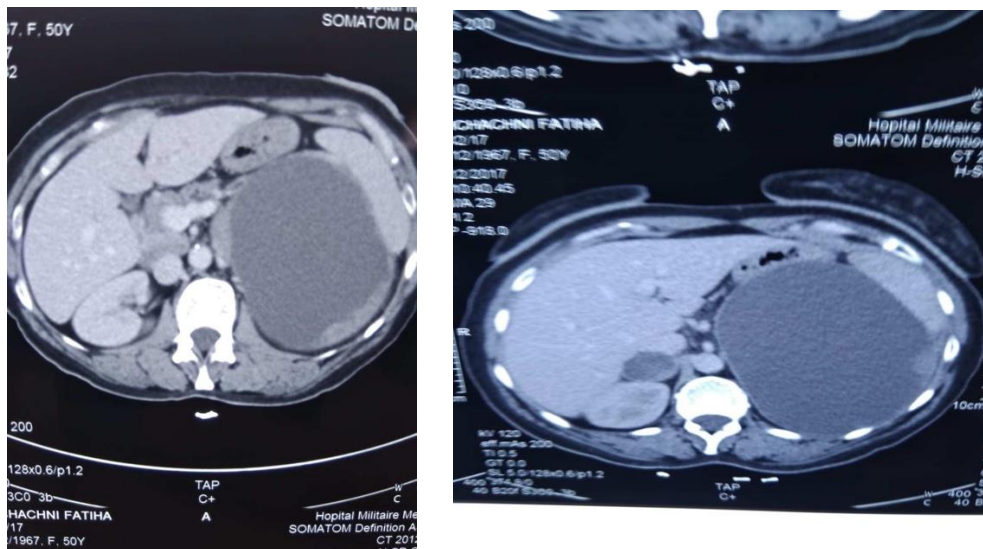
Abdominal CT scan showing a large left adrenal cystic mass displacing the left kidney and the stomach.
